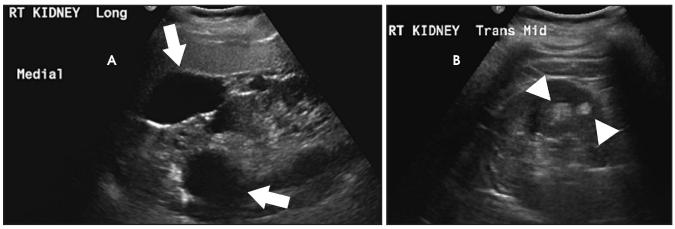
A 42-year-old man with tuberous sclerosis. Longitudinal (A) and transverse (B) ultrasound images of the right kidney demonstrate multiple cysts (arrows) and angiomyolipomas (arrowheads) consistent with the diagnosis of tuberous sclerosis. The left kidney was removed after spontaneous rupture of an angiomyolipoma
